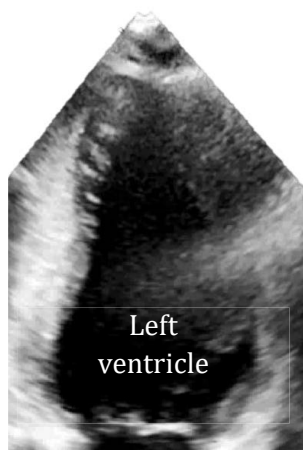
Echocardiographic apical two chamber view - Focused left ventricle
